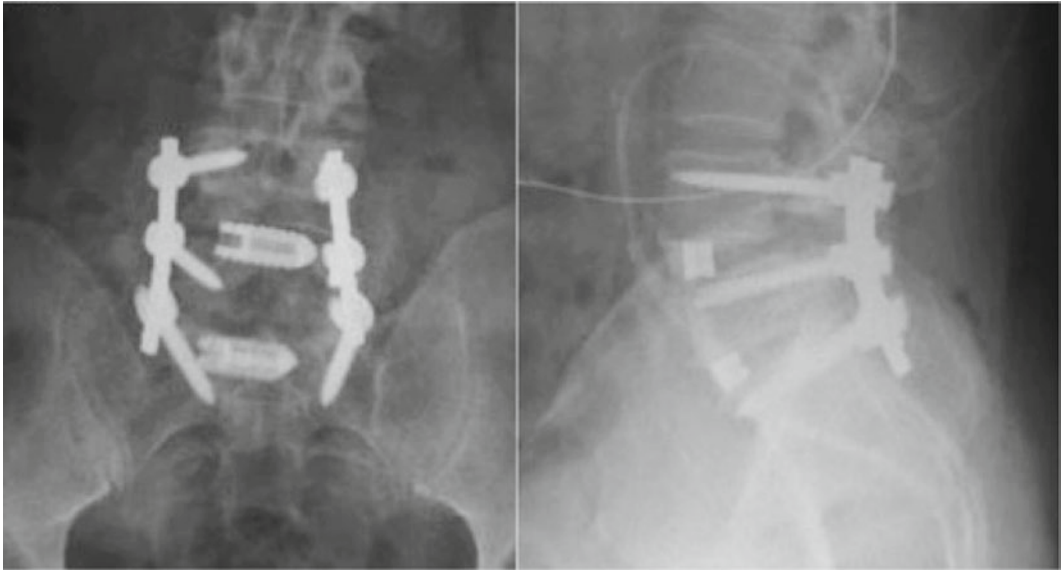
Case example postoperative imaging. Postoperative AP (a) and lateral (b) radiographs following L4–L5 and L5–S1 TLIFs. Complete posterior column osteotomies were performed at each level; discectomy and cage placement were performed from the right side at
